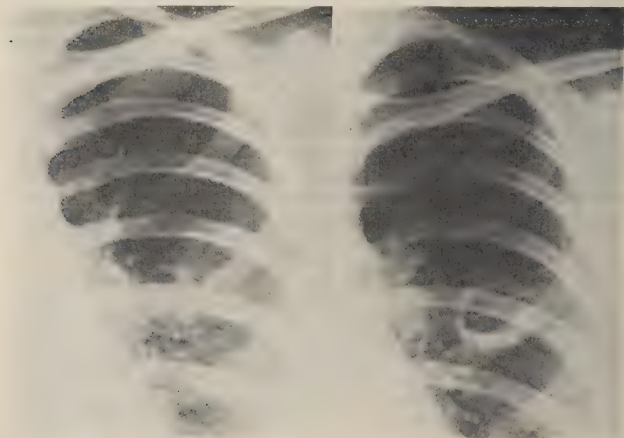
(Case 2). A (Left). Roentgenogram exhibiting a fine exudative lesion in the second left space anteriorly and behind the third and fourth ribs adjacent to the root.
